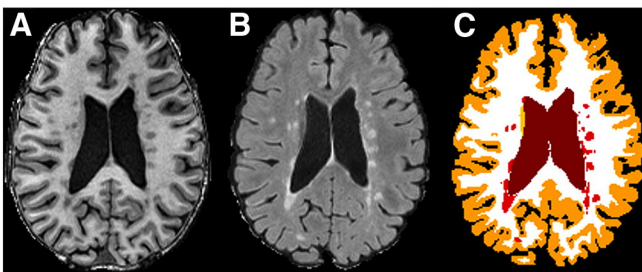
Representative A) T1-weighted (FSPGR), B) T2-FLAIR, and C) lesion-TOADS classification images. The lesion-TOADS image shows classification of cortical gray matter (orange), white matter (white), ventricles (brown), and lesions (red). (For interpretation of the references to color in this figure legend, the reader is referred to the web version of this article.)
